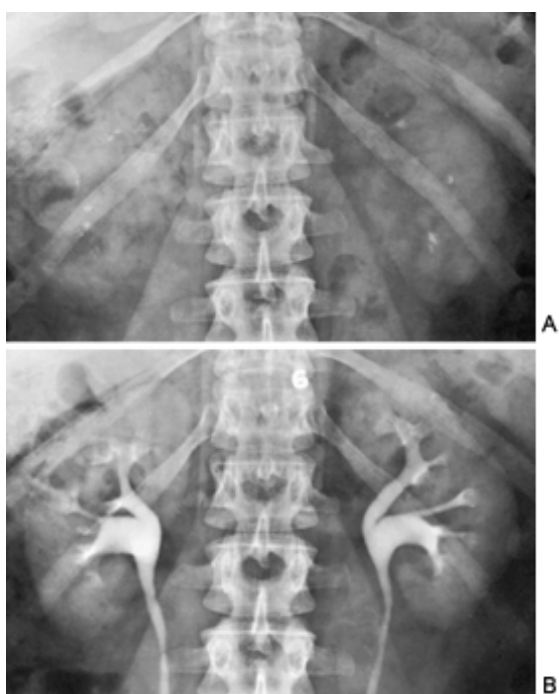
Medullary sponge kidney. A: A plain abdominal radiograph reveals bilateral nephrocalcinosis. The calculi are located at the papillary tips. B: An intravenous pyelogram in the same patient reveals linear radiations from the calyces. These radiations result from stagnation of contrast medium in the cystic or dilated collecting ducts.
